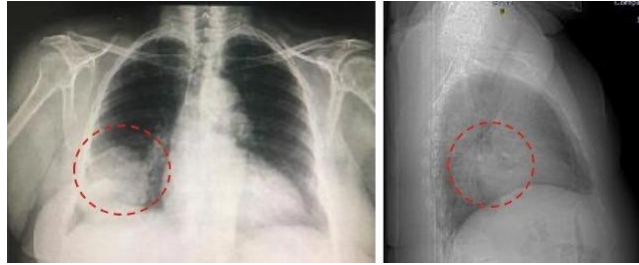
Chest X-ray, posteroanterior view; oval mass-type parenchymal lesion, radiopaque, with smooth borders, located in the lateral basal segment of the right lung.
